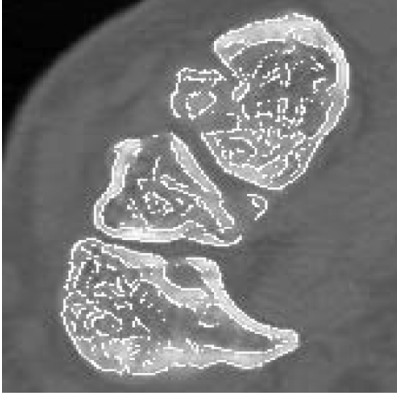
Detected initial seeds (white points) by (20) in a CT slice of a human pelvis.
